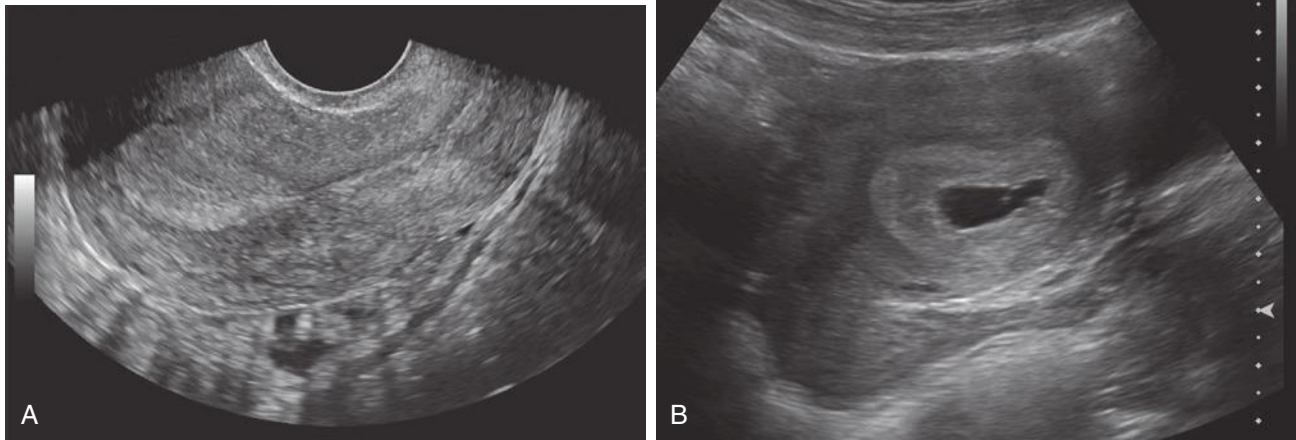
A, Transvaginal sonogram obtained at approximately 4.5 weeks demonstrating no evidence of an intrauterine pregnancy. Additional scans revealed normal ovaries without evidence of an adnexal mass. B, Transabdominal sonogram obtained 1.5 weeks later revealed a living intrauterine pregnancy.
